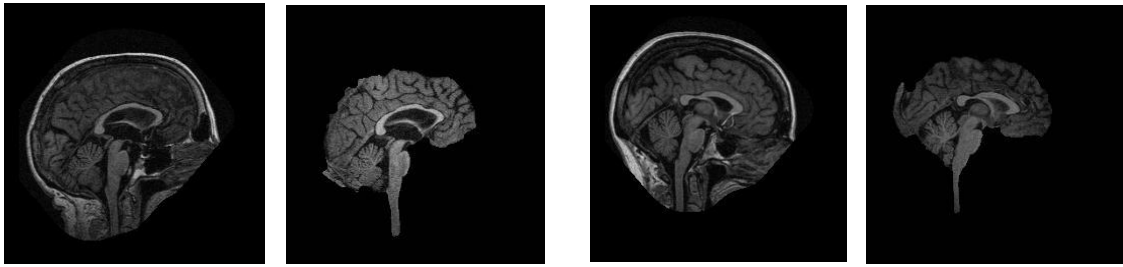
The above images are examples of skull-stripping for non-AD MR images
